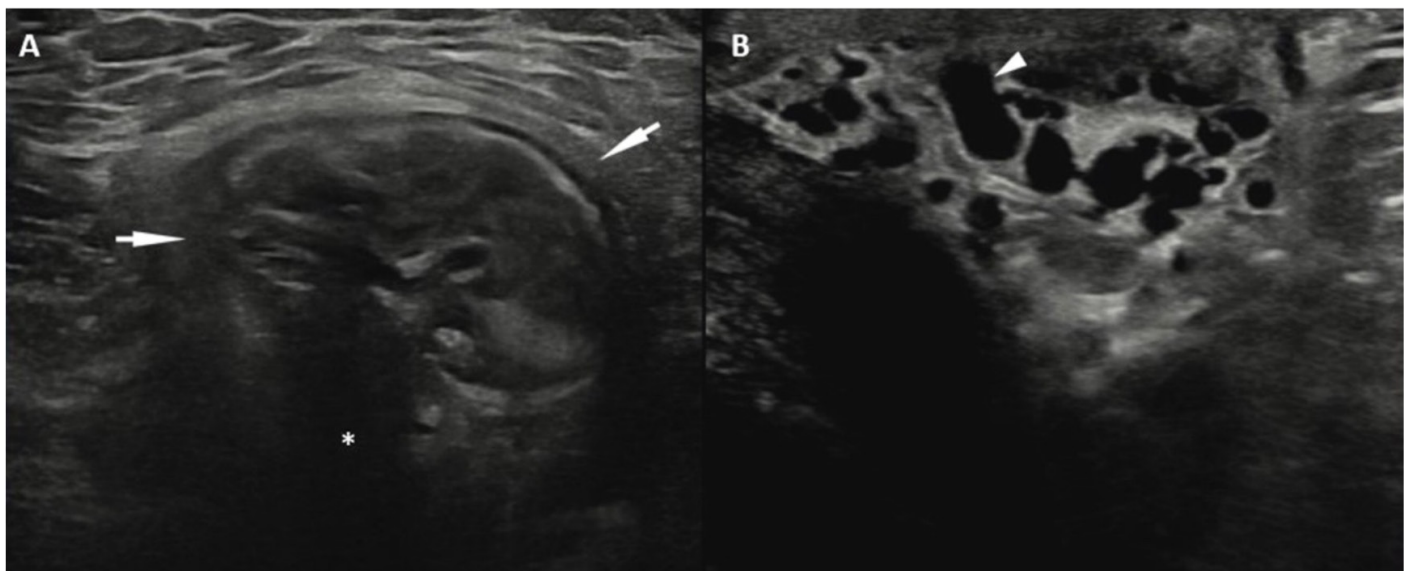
Ultrasound examination shows marked inguinal hernia (A, arrows) with neck of hernia (A, star) and accompanying enlarged pampiniform plexus veins consistent with varicocele (B, arrowhead)
